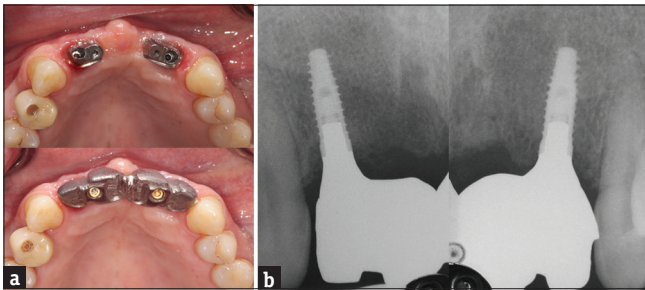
(a) Intra-oral view of abutments and superstructure. (b) Radiographic view confirming abutments fit
